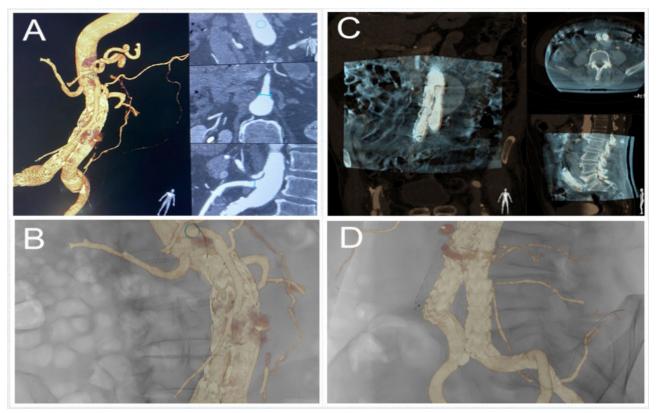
CT- angiography (CTA) with "vessel navigation" engine equipped with a co-registration and navigation software "Fusion" (A); coupling of live images acquired during the procedure with the pre-operative CTA scan images (C); examples of Fusion-guided cannulation of target vessels (B, D).
